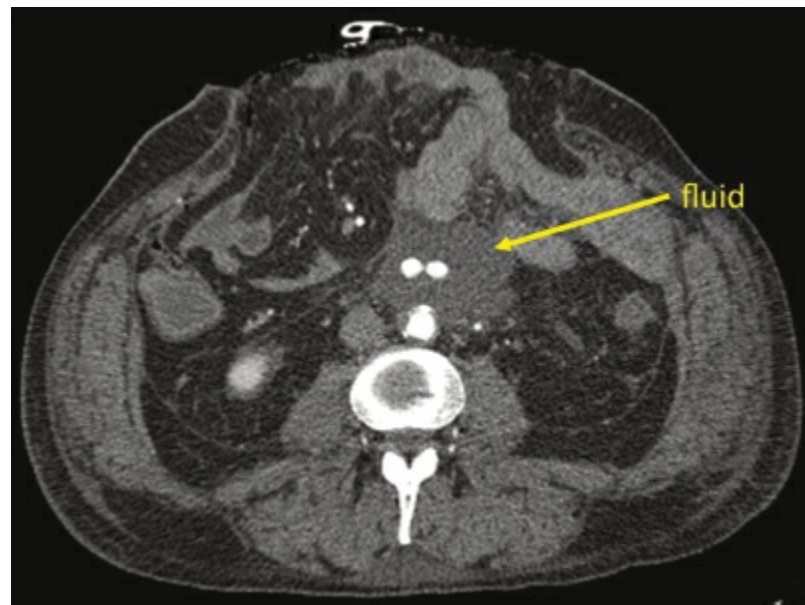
CT scan demonstrating perigraft fluid surrounding a prosthetic aortic graft as a sign of an aortic graft infection.
